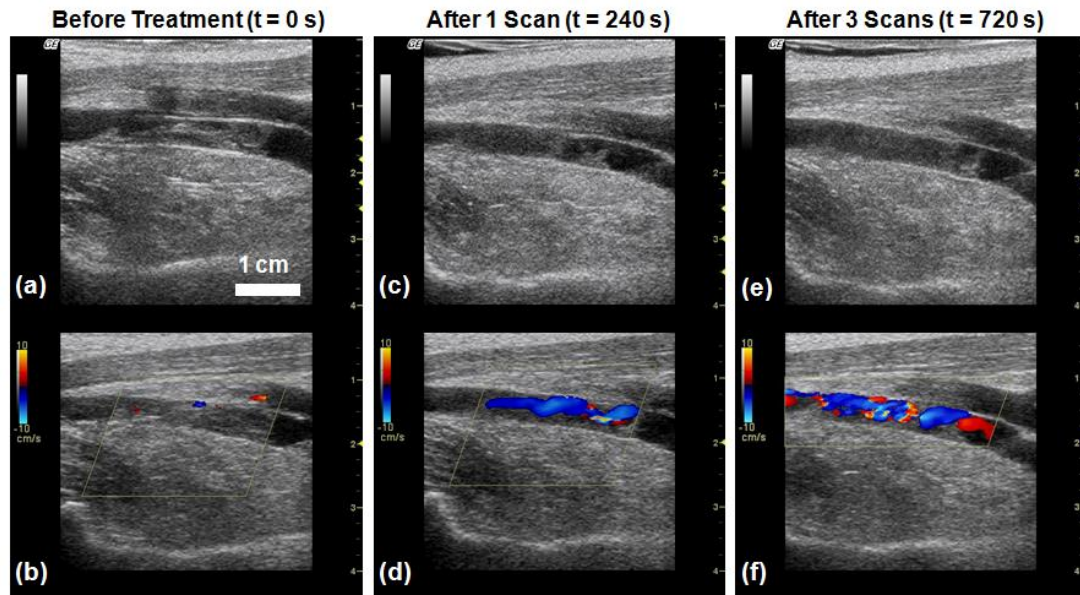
Ultrasound images of the femoral vein captured by a linear array imaging probe between treatments of a fully occlusive thrombus. (a) and (b) show the original appearance of the vessel on 2D imaging and with color Doppler. (c) and (d) show the thrombus after 240 seconds of treatment (one scan). (e) and (f) show the final condition of the clot after 720 seconds (three scans). Note the decreased echogenicity in the lumen on (c) and (e) compared with (a). Also, a flow channel is clearly visible on (d) and (f), while none was present before treatment in (b).
